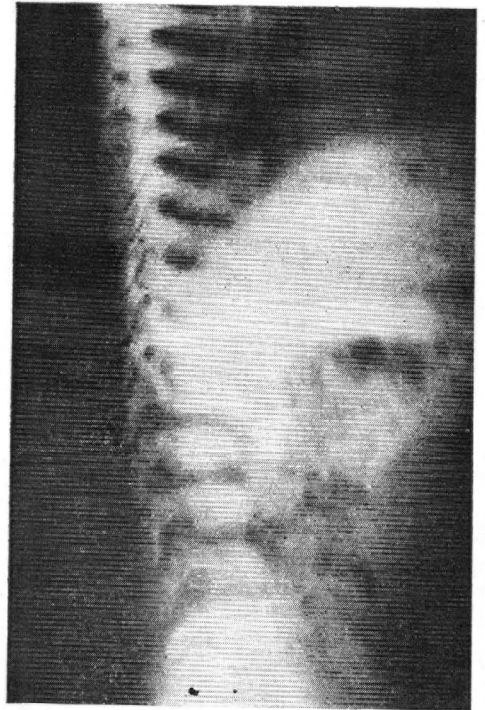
X-Ray spine lateral view - showing vertebra plana, 6 lumbar vertebrae, beaking of L4 and osteoporosis.
